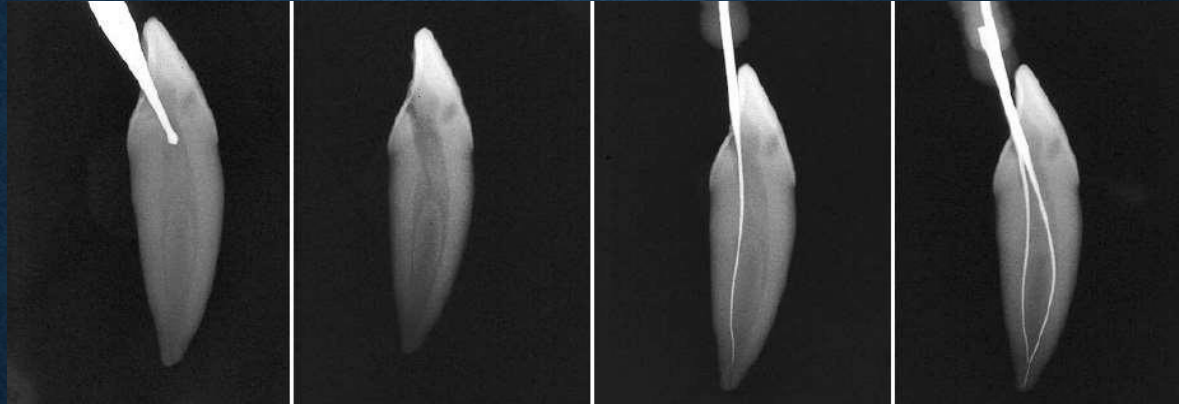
Radiographic appearance of the lower incisor in a mesiodistal projection. A. Medial access cavity has been created. B. A file enters the buccal canal, though with considerable coronal interference. The presence of "buckle 2" impedes the entrance of any instrument into the lingual canal. C. The low-speed round bur completely enters the distal triangle. D. Radiographic appearance of the completed access cavity. E. The file can now enter the lingual canal easily. F. The two root teeth confirm the presence of two canals with a coronal apex.
